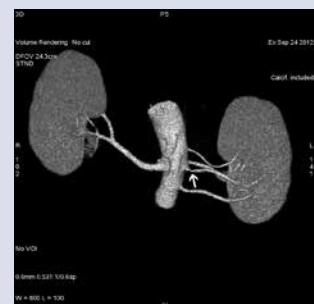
CTA of the renal arteries. Left kidney provided by four renal arteries, one of them with 50% proximal stenosis (arrow)
